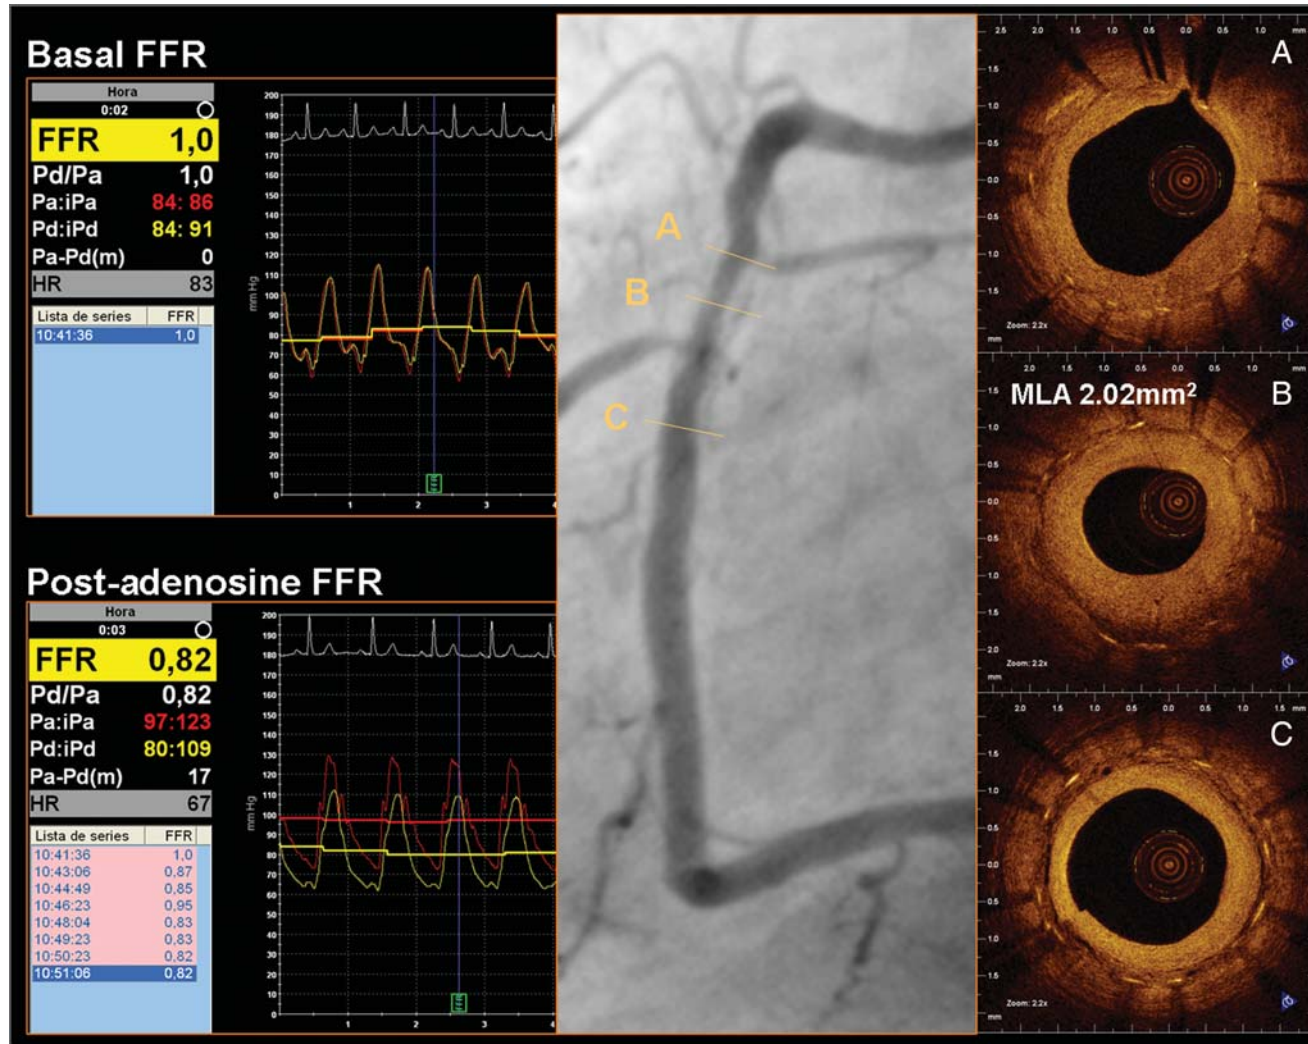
A 51-year-old male with non-ST-segment elevation myocardial infarction was treated with implantation of a bare-metal stent. Six months later, the patient complained of exertional Canadian Cardiovascular Class II angina. Single-photon emission computed tomography showed an inferior perfusion defect after exercise. Optical coherence tomography showed severe restenosis of the stent, with predominantly homogeneous density, compatible with fibrous tissue, low peri-strut density, and rich microvasculature around the struts. The point of minimum lumen area (MLA) was 2.02 mm². (B) Fractional flow reserve, however, was 1.0 at basal conditions and 0.82 after maximal vasodilation. The optimal treatment of this case remains controversial.
